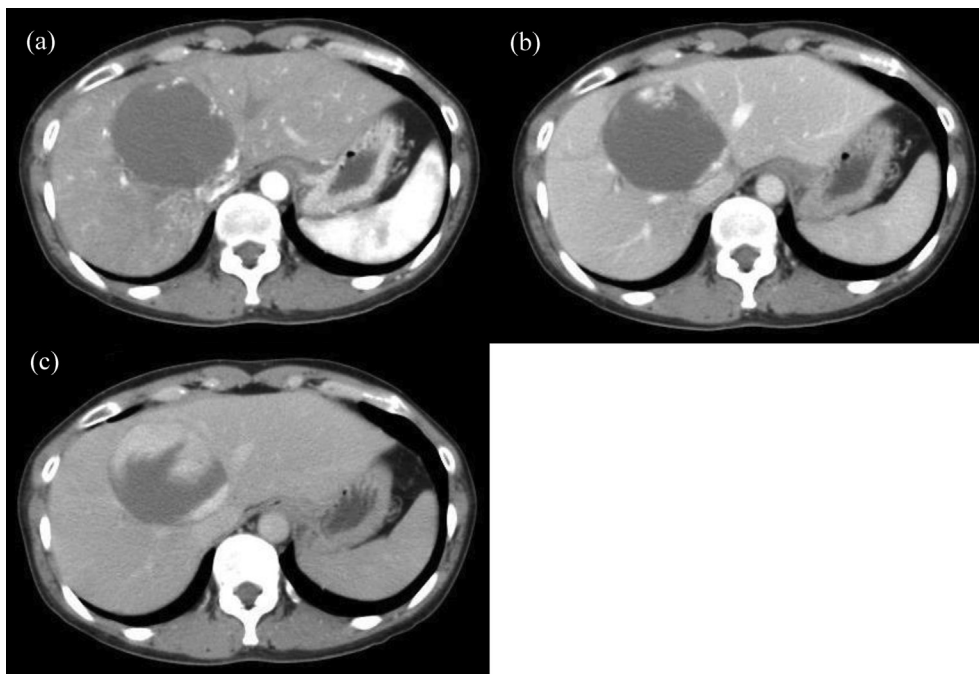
CT showed a giant hepatic hemangioma in the left medial lobe before proton beam therapy. (a) Hepatoarterial phase (b) Portal venous phase (c) Equilibrium phase.
